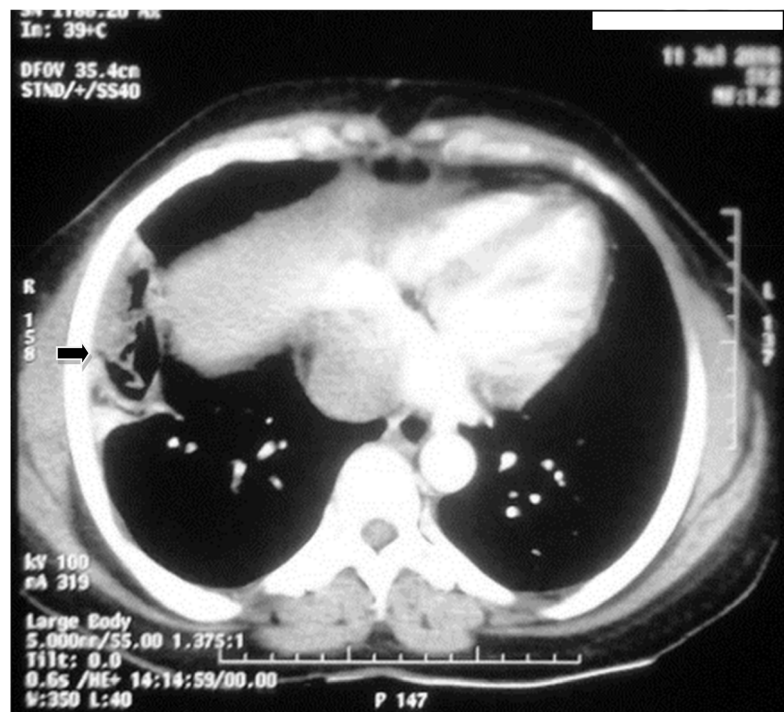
Contrast enhanced axial HRCT image showing a wedge-shaped peripheral opacity (arrow) with irregular internal lucencies in the right middle lobe. There was no pleural effusion.
